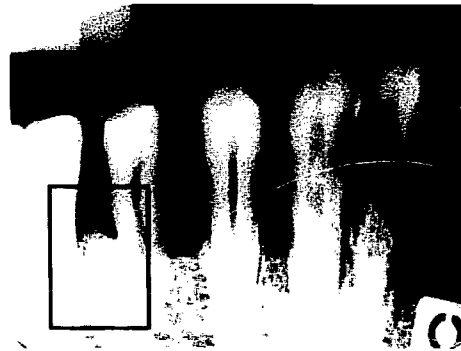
Radiograph with the region to be digitized indicated.
